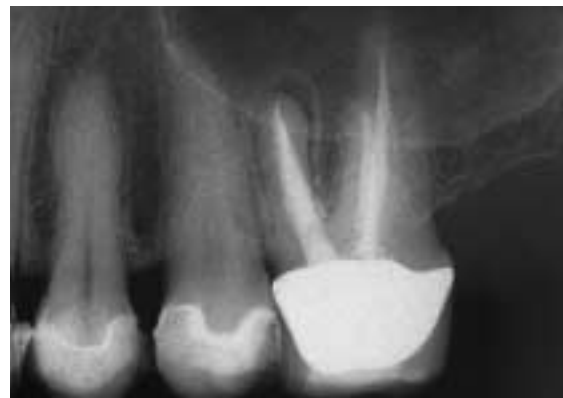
Periapical radiograph after retreatment.
